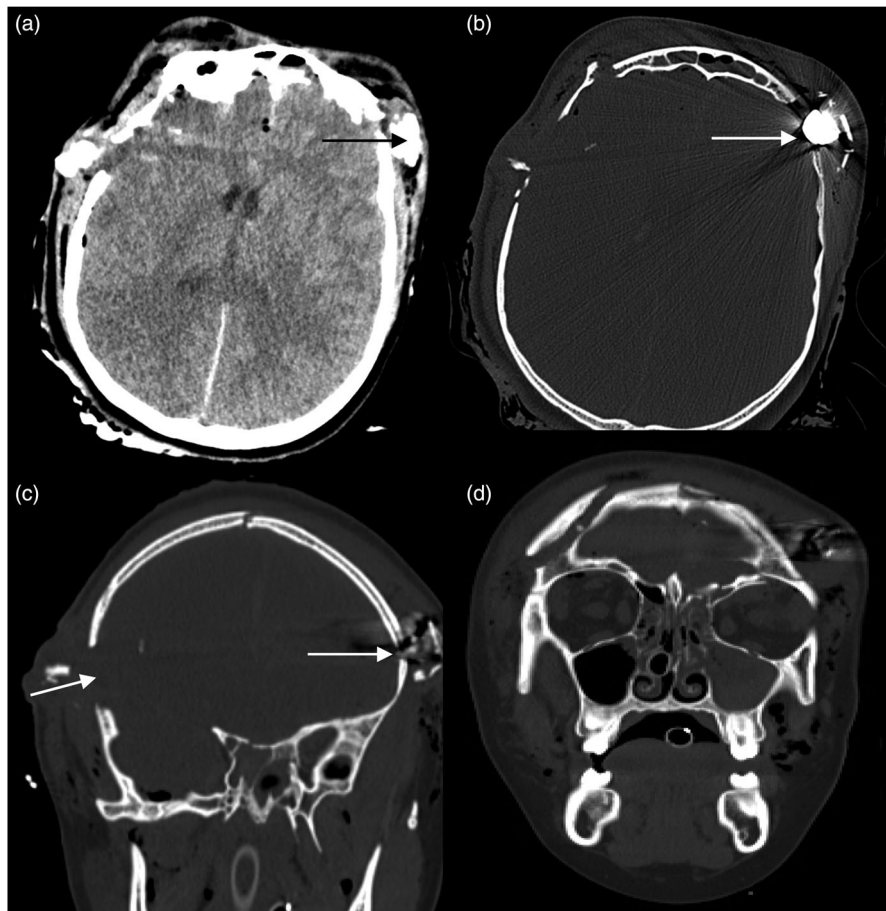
CT head at time of presentation. (a and b) axial non-contrast CT (b bone windowed) demonstrating 'through and through' pattern of shrapnel trajectory, plus retained shrapnel fragment in soft tissue (arrow). (c and d) (coronal bone windowed CT) demonstrating shrapnel entry and exit wounds (c, arrows) plus extent of skull fractures.
